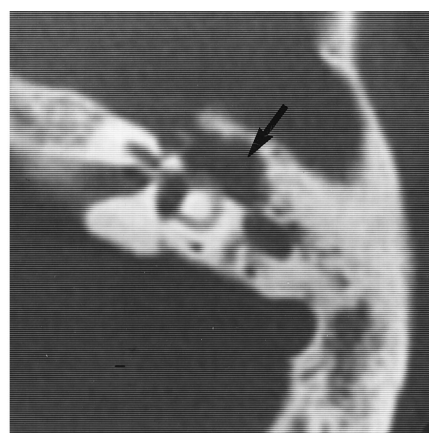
Acquired atticotympanic cholesteatoma. Axial CT scan shows a soft-tissue mass within the left attic extending anteriorly to involve the anterior epitympanic recess and eroding the cog and the ossicles (*arrow*).
